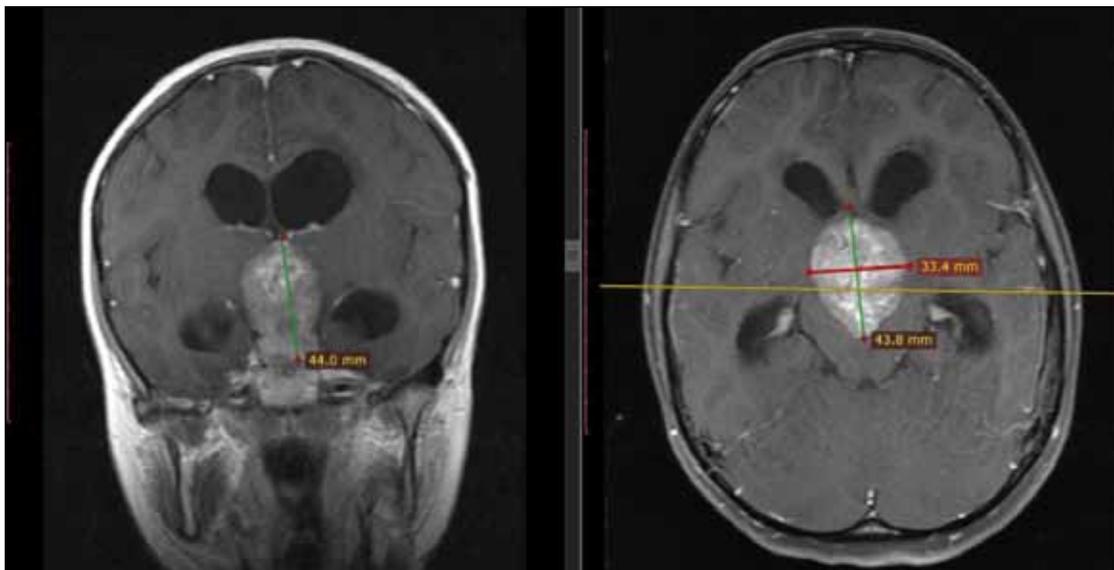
Preoperative coronal (left) and axial (right) contrast-enhanced MRI; T1-weighted images with contrast demonstrated heterogeneous enhancement after contrast, well-circumscribed and measuring 43.8x33.4x44 mm and there was obstructive hydrocephalus.
